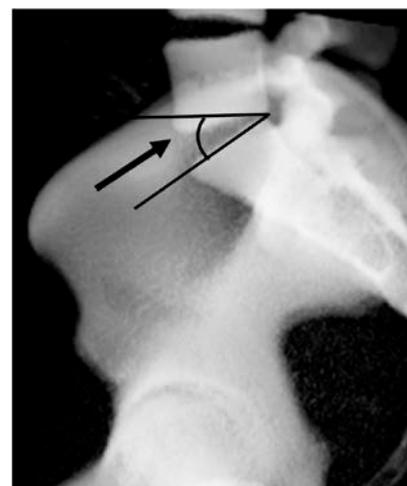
Lateral radiograph of pelvis showing SS measurement. (SS angle (shown by an arrow) was defined as the angle between the line parallel to the superior end plate of sacrum and horizontal line)
